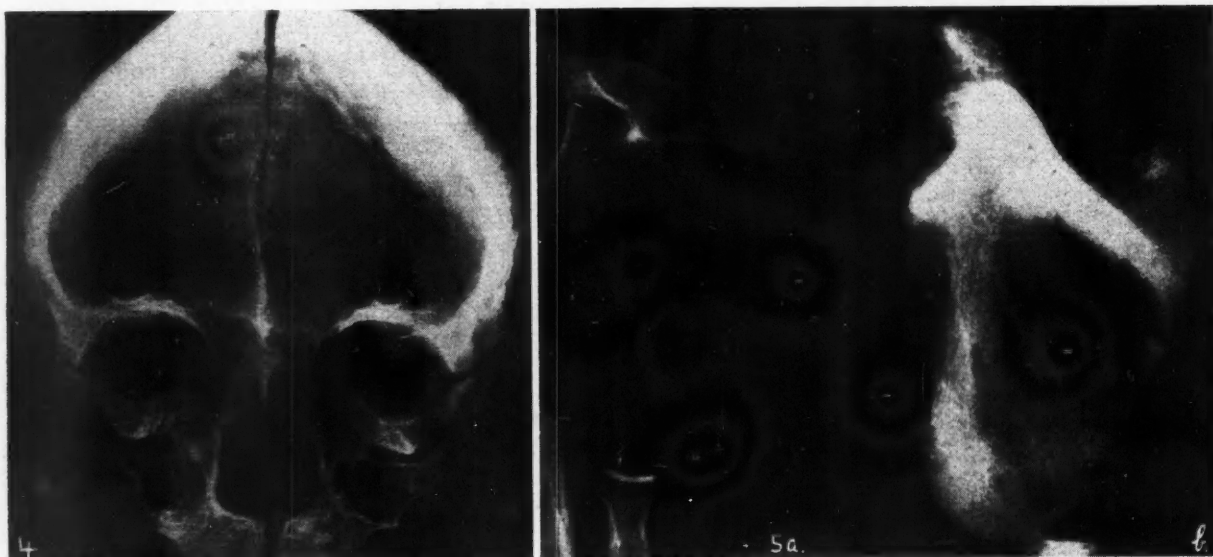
Radiogram of skull bones from case of advanced fluorosis. The bones were re-assembled for the picture. Fig. 5.—(a) X-ray of normal scapula. (b) Scapula from case of advanced fluorine intoxication. The exposure for the two bones is the same.
